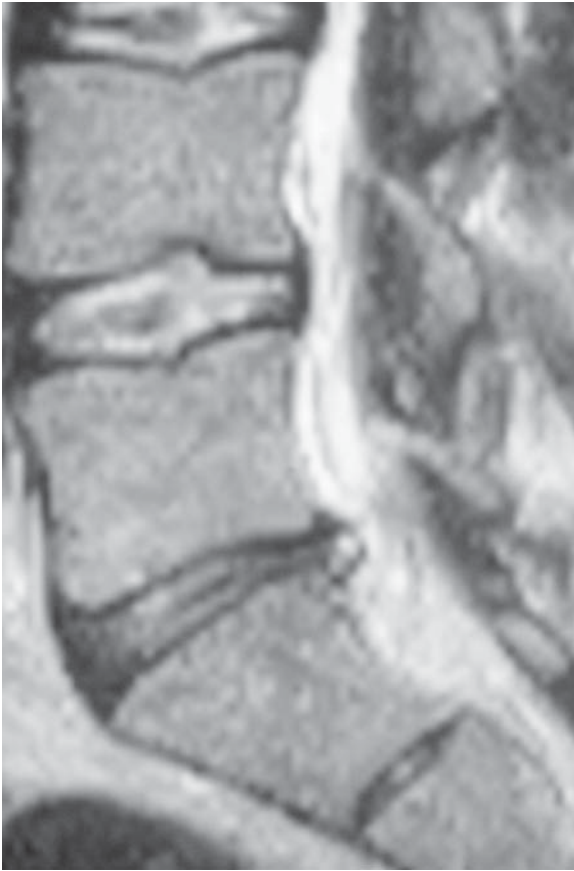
Sagittal T2 MRI showing an area of bright signal in the posterior annulus fibrosis of the L5-S1 disc. This represents a high-intensity zone (HIZ).
